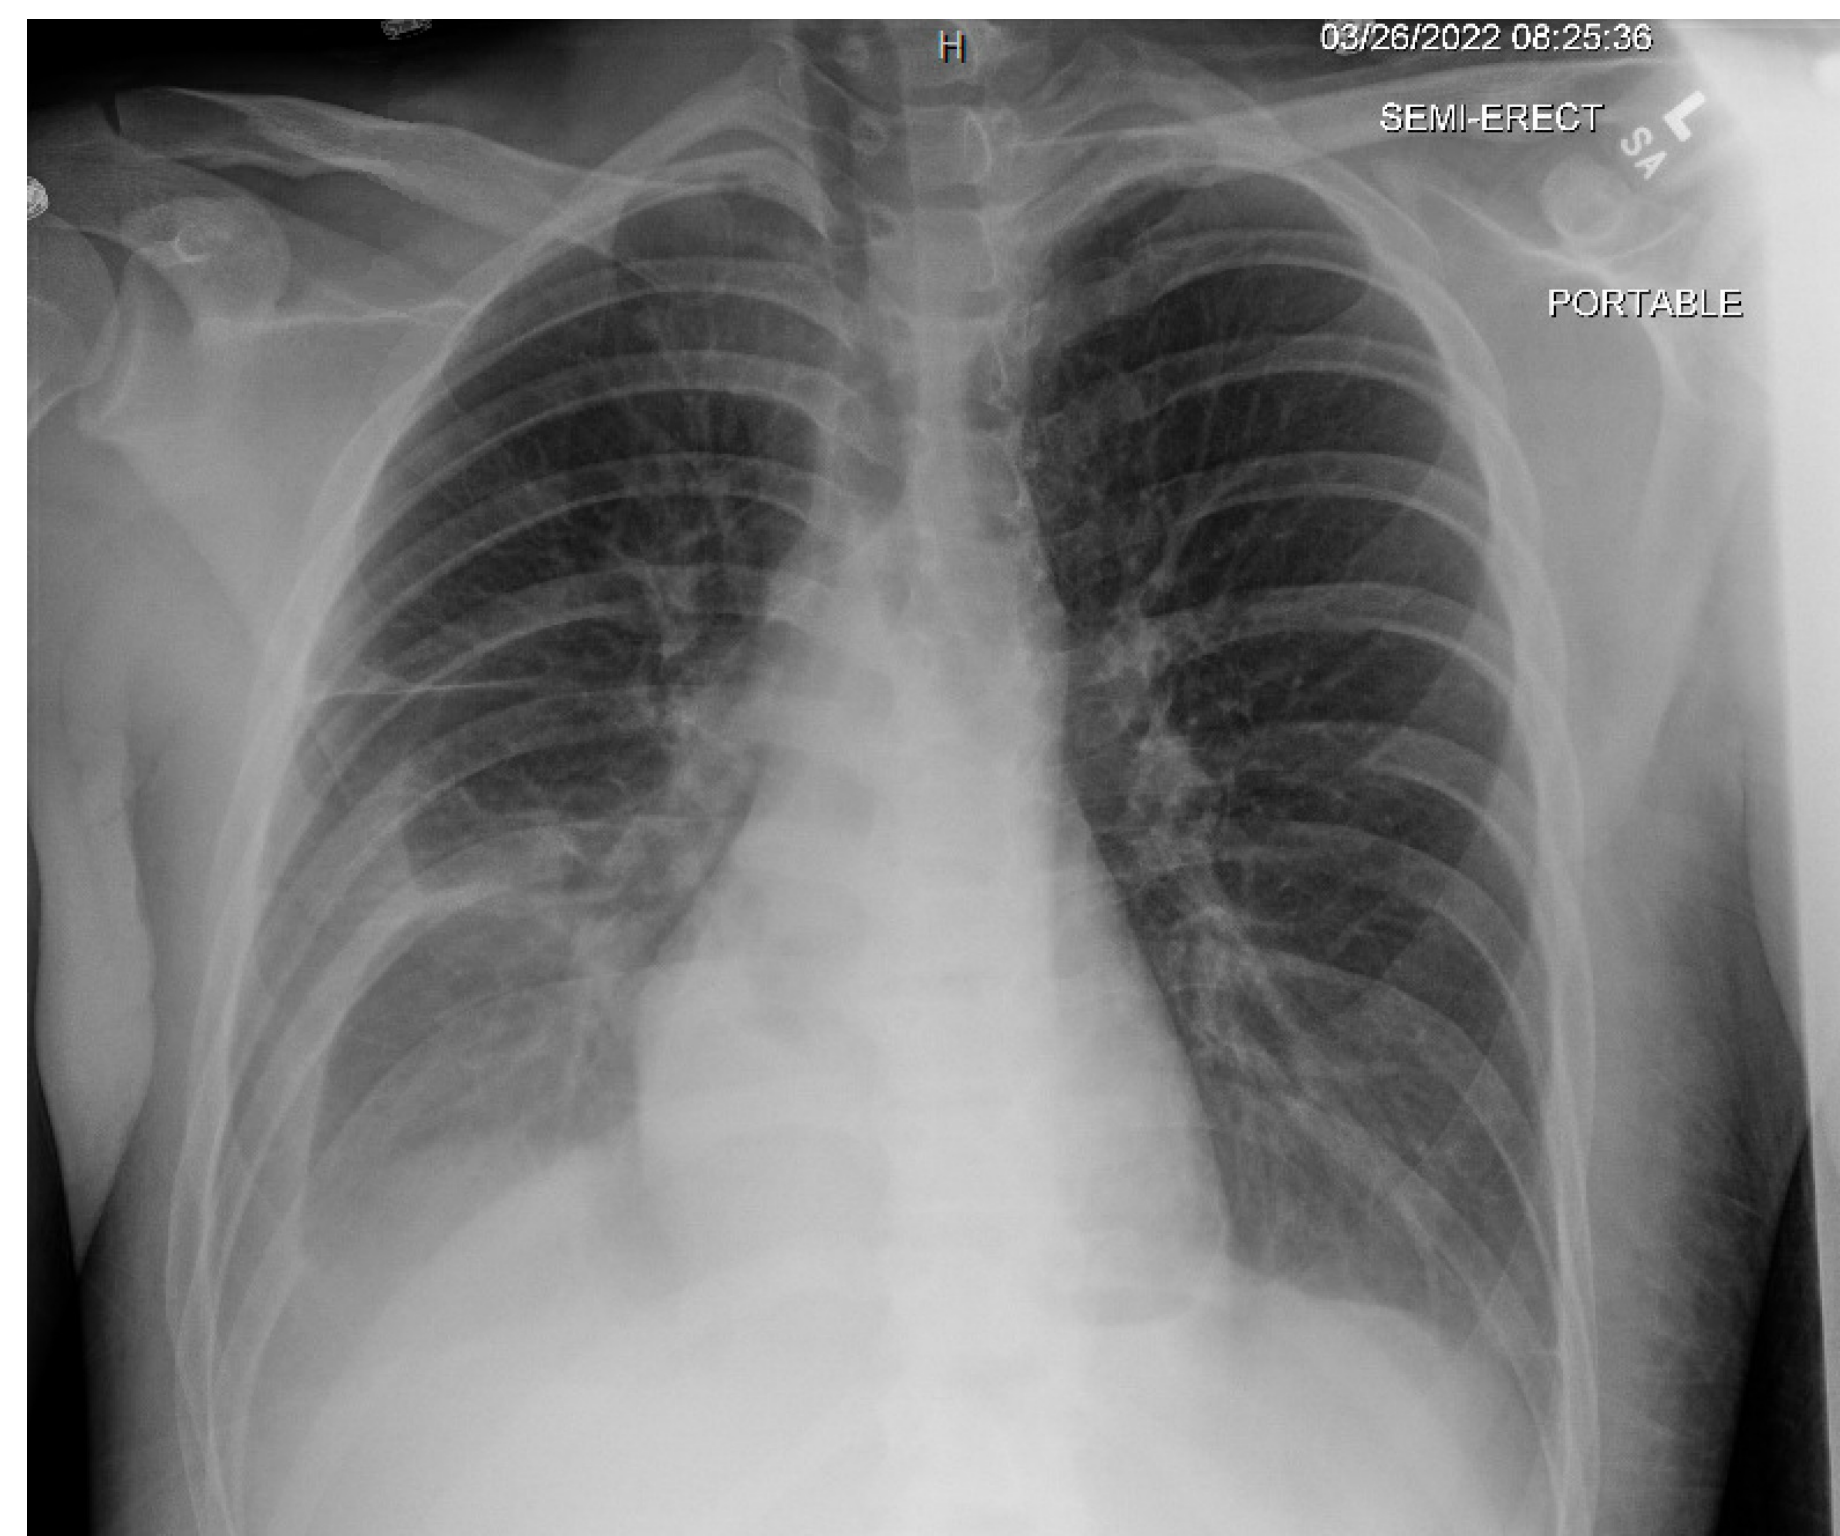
Bilateral Pleural Effusions on chest X-ray.
